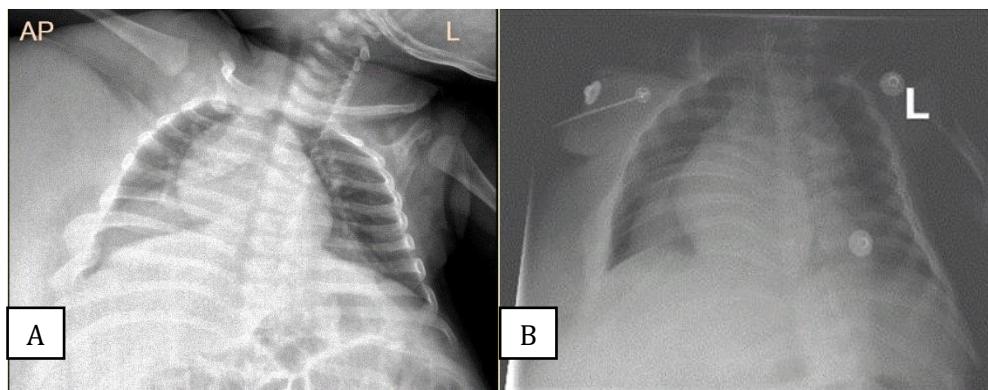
B AP chest radiographs obtained one week apart. The first image demonstrates a wedge-shaped opacity predominating in the right lower zone, suggestive of right lower lobe collapse. A follow-up portable chest X-ray shows similar findings with additional hazy opacities in the left lower zone. These appearances are consistent with pneumonia. A soft-tissue mass is visible along the right lateral chest wall
